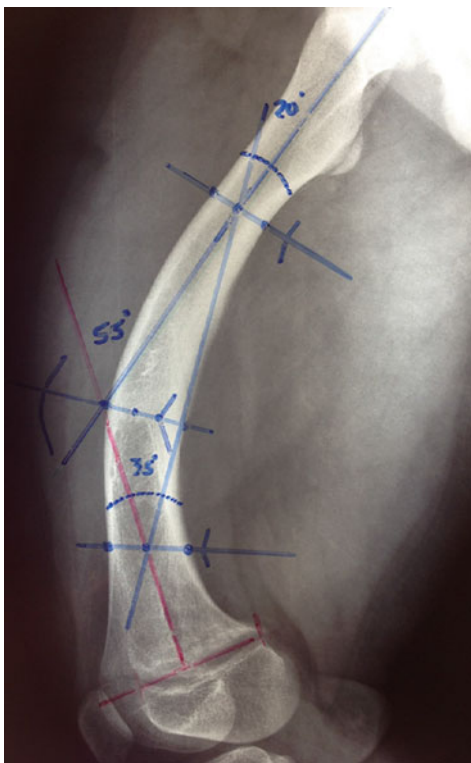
Preoperative planning of right femur, lateral X-ray showing multiapical deformity. The total deformity is 55° but resolves best to a proximal deformity of 20° and a distal deformity of 35°
